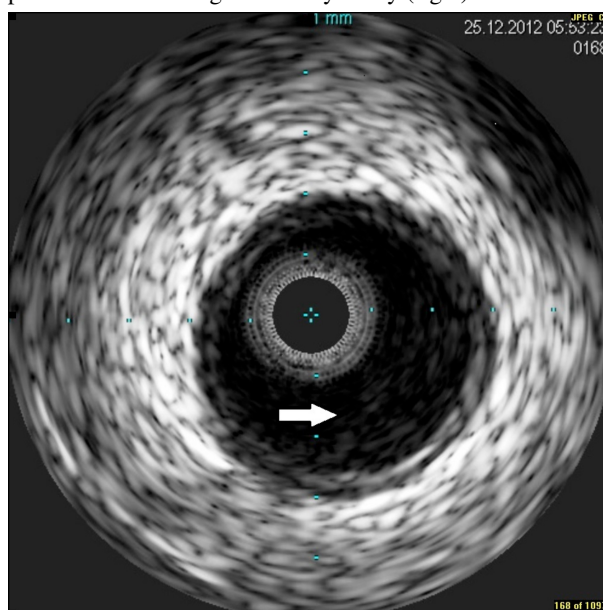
Intravascular ultrasound of proximal right coronary artery showing luminal thrombus (arrow) adherent to the artery wall, with no evidence of atheromatous plaque or dissection
